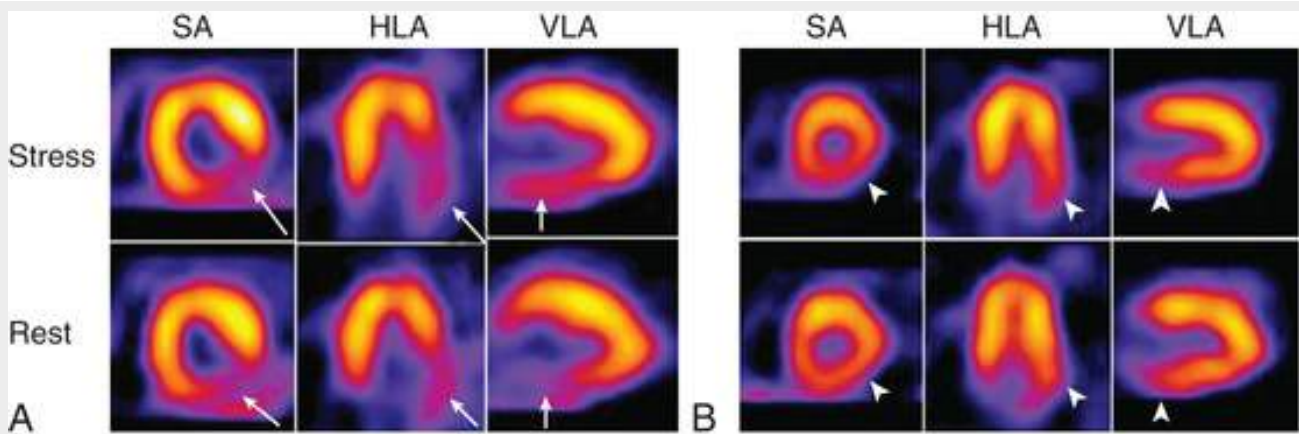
Examples of SPECT stress/rest perfusion imaging findings of infarct and ischemia. A, Fixed defect of the inferolateral wall (*arrows*), with similar reduction in tracer uptake in both stress and rest images in short-axis (SA), horizontal long-axis (HLA), and vertical long-axis (VLA) views, findings consistent with infarct. B, Reversible defect of the inferolateral wall (*arrowheads*), with relative reduction in tracer uptake in the inferolateral wall compared to the other walls in the stress images, with more homogeneous uptake in the rest images. These findings are consistent with blunted flow reserve in that area during stress, with normal perfusion at rest, identifying an area of stress-induced ischemia.
